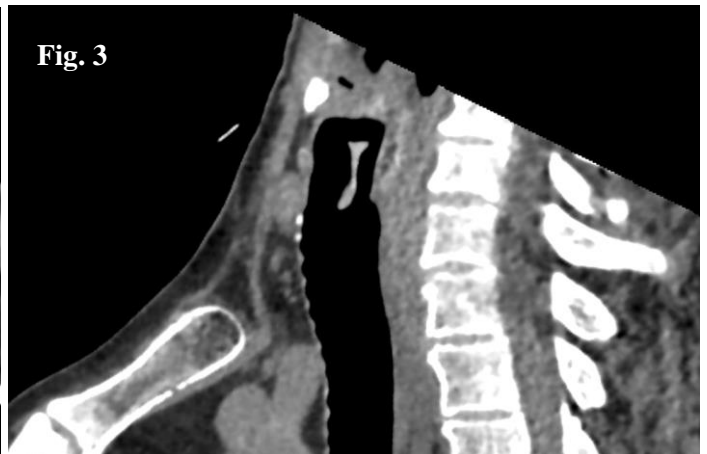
Coronal, Sagittal and Axial CT scan showing a foreign body located in the subglottic region.
